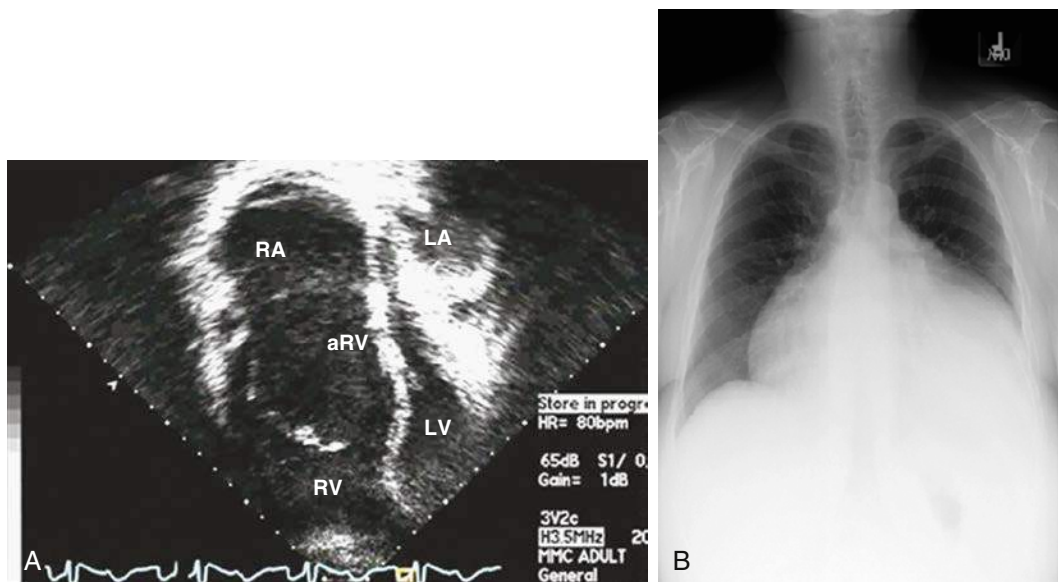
A, Two-dimensional (2D) echocardiogram in a four-chamber view with the apex pointing down. The enlarged RV and atrialized RV are displacing the ventricular septum leftward, causing severe compression of the LV cavity B, Chest radiograph of a 49-year-old patient with Ebstein anomaly with severe right atrial and ventricular enlargement. aRV, Atrialized right ventricle; RV, functional right ventricle; LA, left atrium; LV, left ventricle; RA, right atrium.
